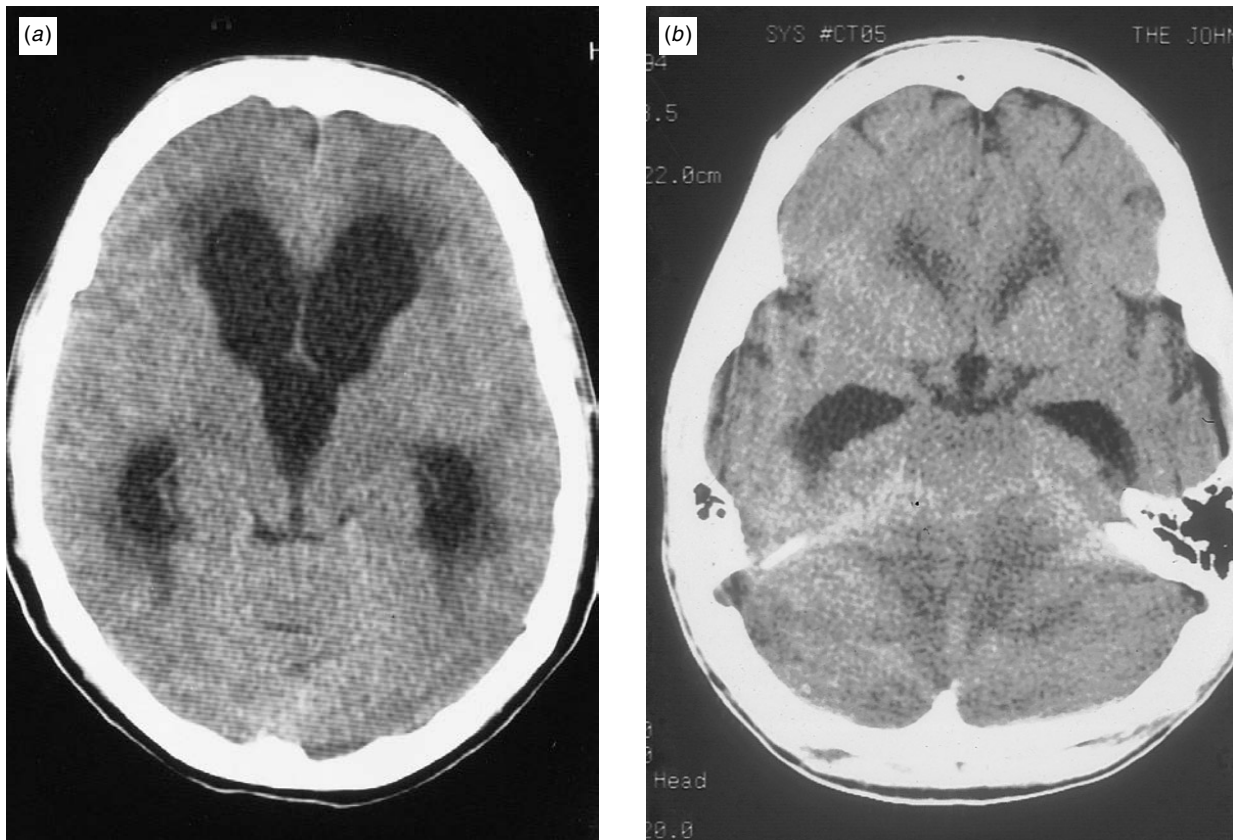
(a). Head CT scan of a 36-year-old woman with obstructive hydrocephalus. There is dilatation of the bilateral frontal and temporal ventricles. The third ventricle is also oval and dilated. Transependymal edema is noted in the frontal and temporal horns. Fig. 125.6(b). Same patient. Lower cut. The perimesencephalic cisterns are effaced.
